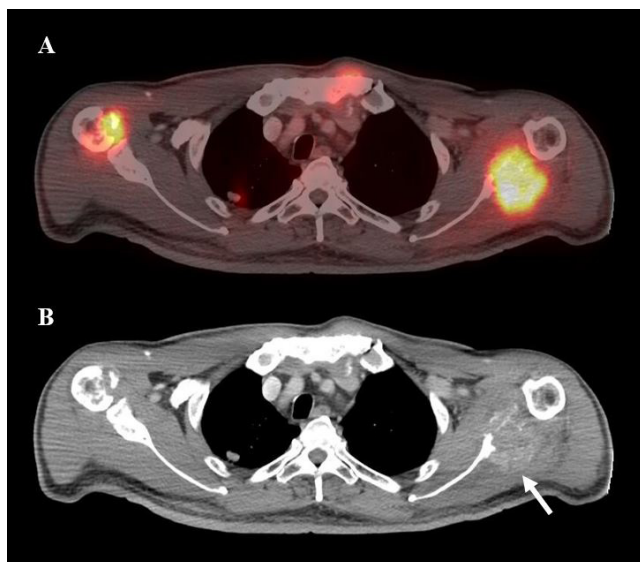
PET/CT scan (A) Axial view of fused image showed hypermetabolic bone lesions at sternum, right humeral head and left scapula and a hypermetabolic pulmonary nodule at right upper lobe. (B) CT image show bone destruction at right humeral head and destructive lesion with soft tissue formation at left scapula where the ultrasound-guided biopsy was performed (arrow).
